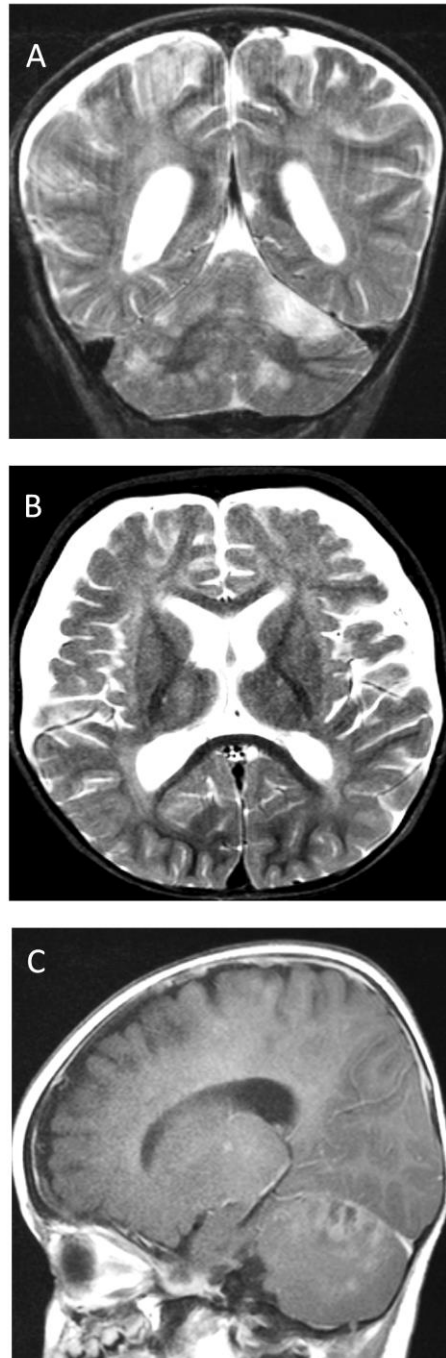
3: MRI brain scan findings in A2.
